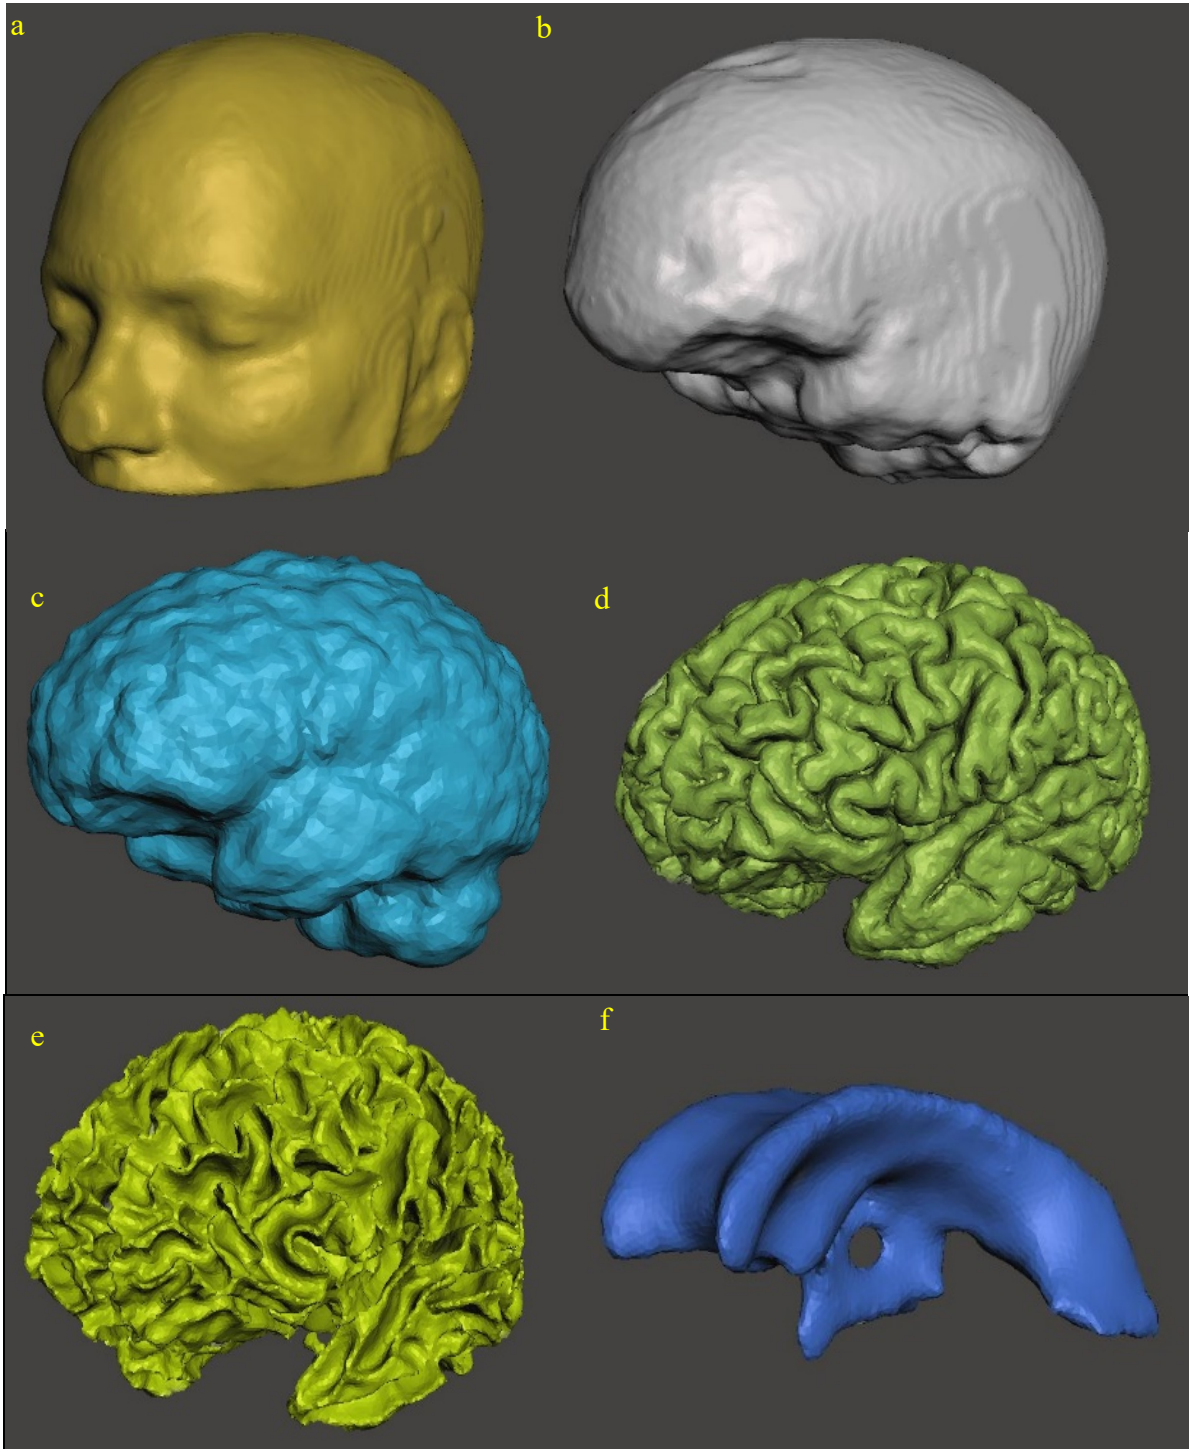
MRI image segmented into the (a) skin, (b) skull, (c) CSF, (d) grey matter GM, (e) white matter WM, and (f) ventricles. The scales of the segmented models are modified and do not reflect the actual scales
